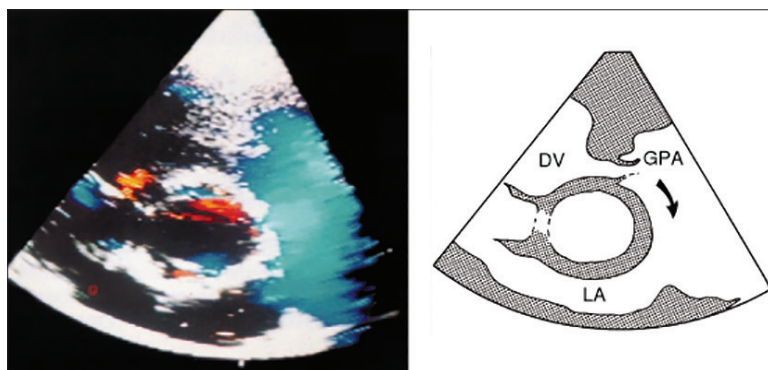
Color Doppler: short axis of systole transverse: flow through the main pulmonary artery (GPA); DV – right ventricle; LA – left atrium
